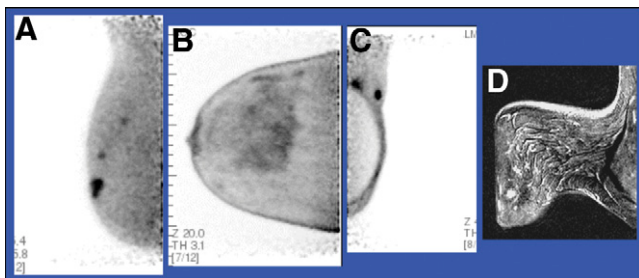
High-resolution positron-emission mammography is useful in presurgical planning for breast cancer by determining extent of disease (A), evaluating indeterminate lesions detected by MR imaging (B and D), and imaging patients with implants or dense breasts (C).
